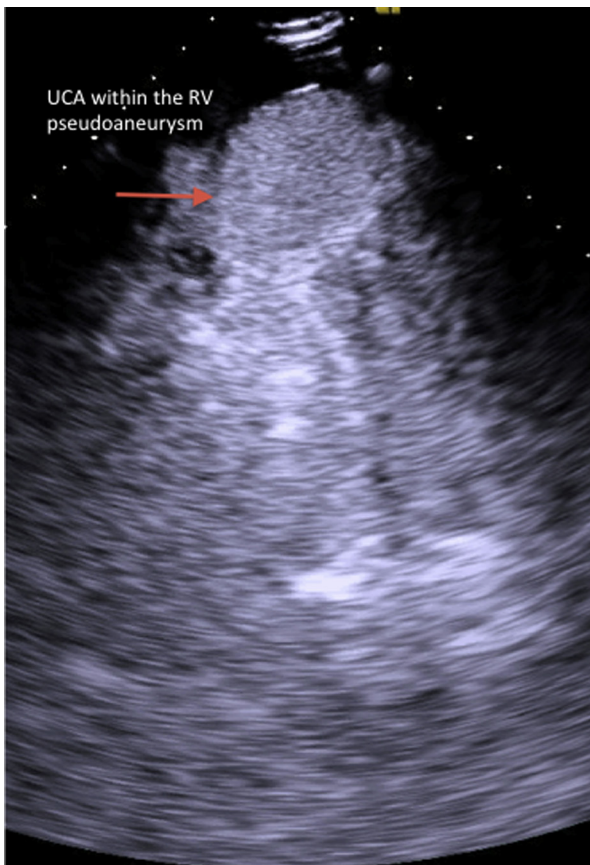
Ultrasound contrast agent (UCA) opacified a structure adjacent to the RV apex that was considered most likely to be a contained RV rupture.
